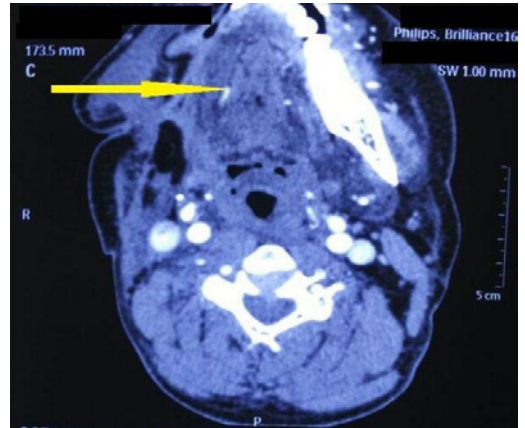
MRI face and neck (2016) showing a 3.2 x 2.8 cm soft tissue mass lesion postero-lateral aspect of hard palate (yellow pointer).
